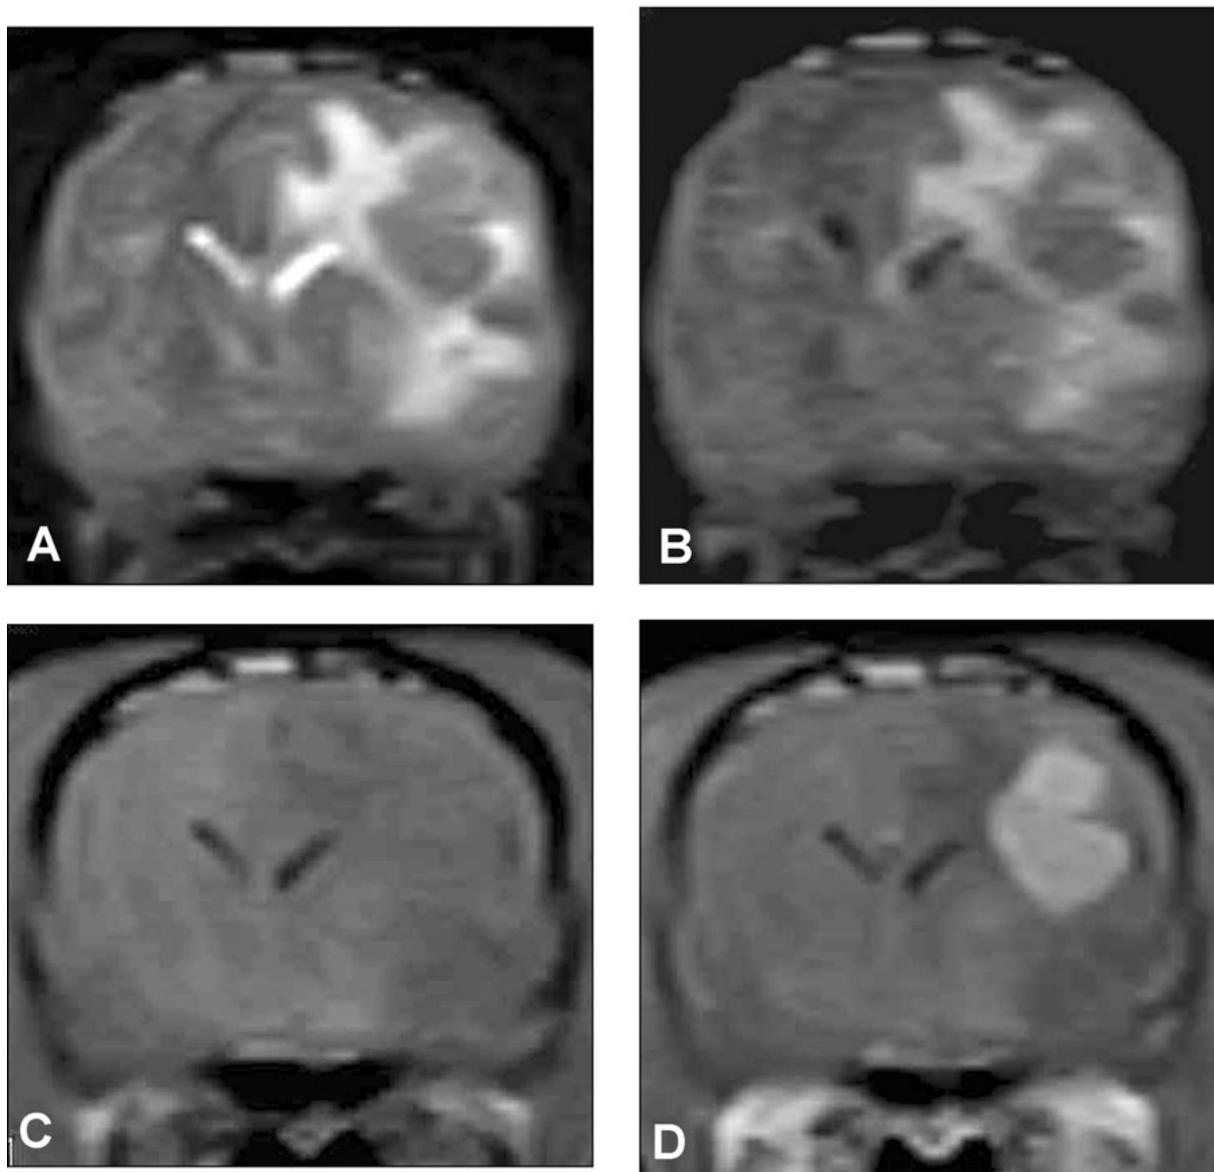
(A) T2W images on the transverse plane. T2W images detecting iso- to slightly low-intensity signals compared to those of the brain parenchyma. The nodular lesion is surrounded by markedly high signal regions. (B) FLAIR on the transverse plane. FLAIR images detecting iso- to slightly low-intensity signals, and the nodular lesion is surrounded by markedly high-intensity signal regions. (C) T1W images on the transverse plane. T1W images detecting low-intensity signals. (D) Gd-T1W images (after an intravenous administration of meglumine gadopentate) on the transverse plane. Intense enhancement is demonstrated.
